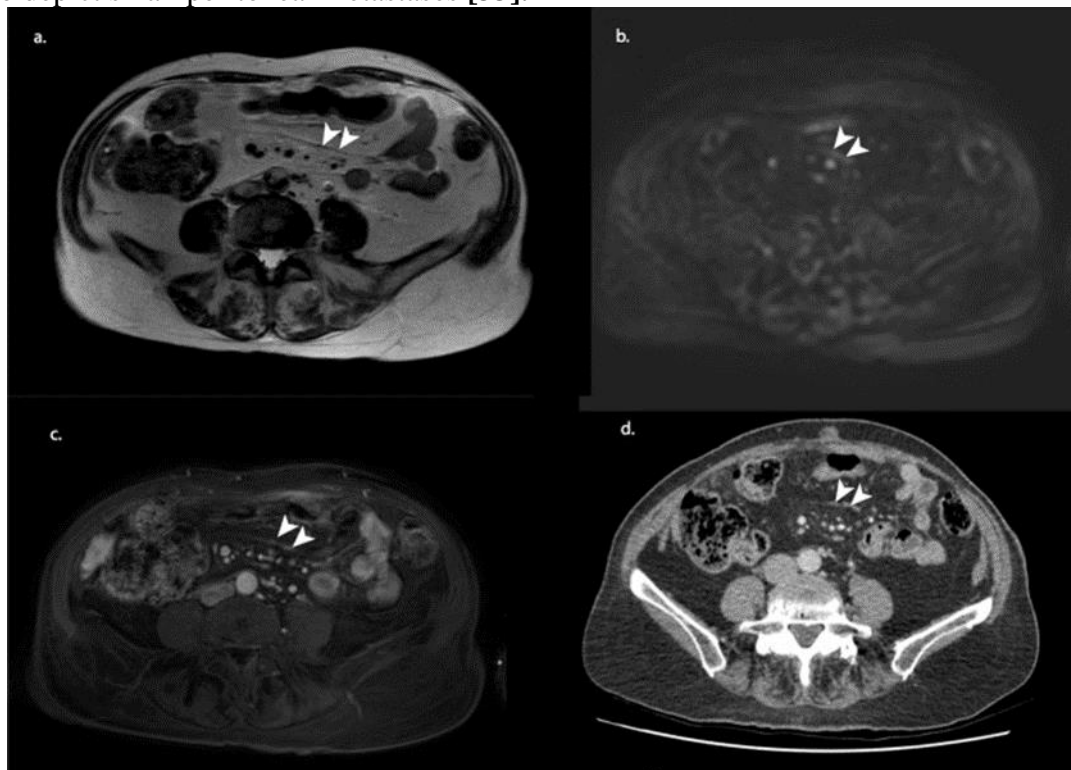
MRI staging example of an 80-year-old female after three courses of neoadjuvant chemotherapy. T2 weighted (a) shows a suspicious dark thickening of the mesenteries (arrowheads), which showed diffusion restriction and contrast enhancement on b1000 diffusion-weighted (b) and gadolinium-enhanced T1 weighted (c) imaging. At CRS, millimetric depositions were found on the mesenteric surface. A CT of 3 weeks earlier showed a similar pattern (arrowheads); however, with CT alone, no confident distinction can be made between ascites, fibrosis or PM. Therefore, the involvement of the mesenteries was not mentioned in the original CT report. CRS, cytoreductive surgery [14].
